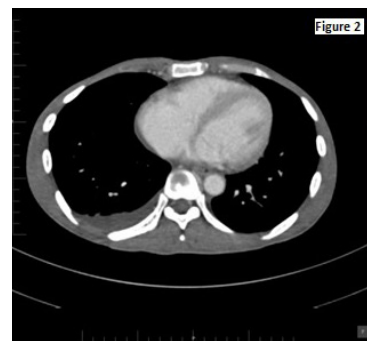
Initial CT chest showed pleural & pericardial effusion.
